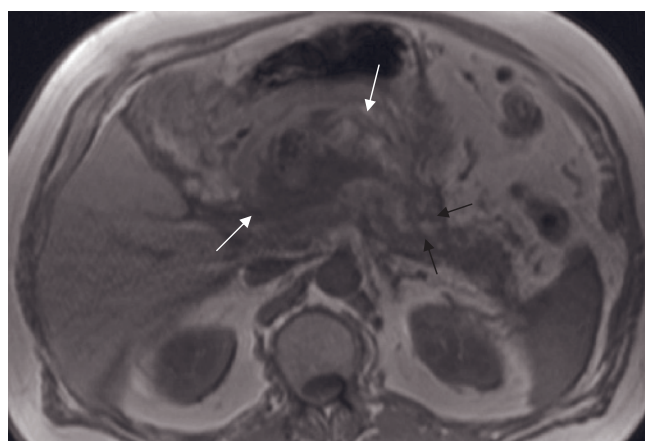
Hemorrhagic pancreatitis. Axial fat-suppressed T2-weighted SS-ETSE (*a*), T1-weighted gradient-echo (*b*), immediate postgadolinium T1-weighted gradient-echo (*c*), and interstitial-phase postgadolinium T1-weighted gradient-echo (*d*) images in a patient with acute pancreatitis. The pancreas demonstrates diffuse hypoenhancement on immediate postgadolinium images, reflecting severe disease. The fluid surrounding the pancreas is hyperintense on T1 (arrows, *b*) and hypointense on T2-weighted images. This appearance is consistent with intracellular methemoglobin seen in subacute hemorrhage. T2-weighted SS-ETSE (*e*), fat-suppressed T1-weighted gradient-echo (*f*), and immediate postgadolinium fat-suppressed T1-weighted gradient-echo (*g*) images
